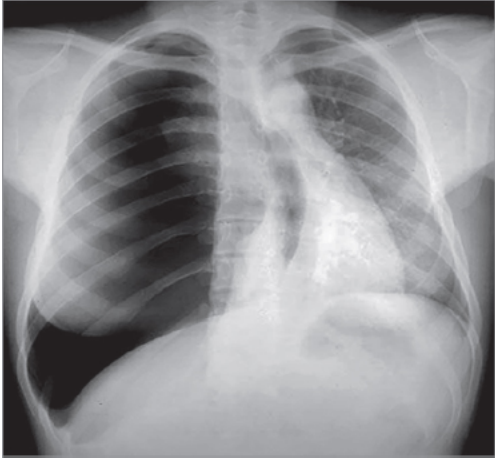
Chest X-ray PA view showing trachea and mediastinum deviated to left, cardiophrenic and costophrenic angles are normal, homogenous hyperlucency in right hemithorax suggestive of right-sided pneumothorax.
